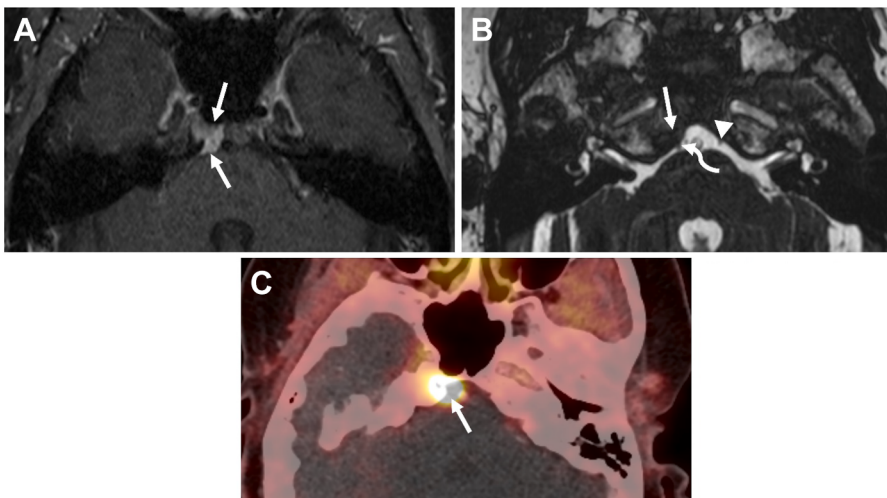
Patient with remote history of tuberculum sella meningioma resection. (A) Postcontrast T1-weighted image of skull base MR show subtle right petroclival dural-based enhancing lesion (arrows), suspicious for meningioma. (B) High-resolution FIESTA-C image of skull base MR depicting the enhancing lesion extension along the right Dorello canal (arrow) and abutting the cisternal segment of right cranial nerve VI with slight medial deviation (curved arrow), compared to the unaffected left cranial nerve VI (arrowhead). (C) Subsequent ⁶⁸ Ga DOTA-TATE PET-CT demonstrates corresponding DOTATATE avidity (arrow), corroborating the presence of meningioma. Subsequent clinical examination revealed right cranial nerve VI paresis. *Abbreviation:* FIESTA-C, Fast Imaging Employing Steady-state Acquisition-C.
